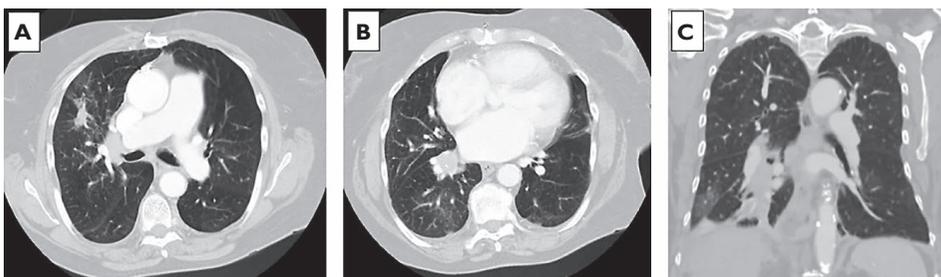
Axial computed tomography (CT) of the chest showing a spiculated lesion in the right upper lobe (A). Endobronchial lesion nearly occluding the right bronchus intermedius was seen (B). Coronal CT scan showed partial atelectasis of right lower lobe (C).
